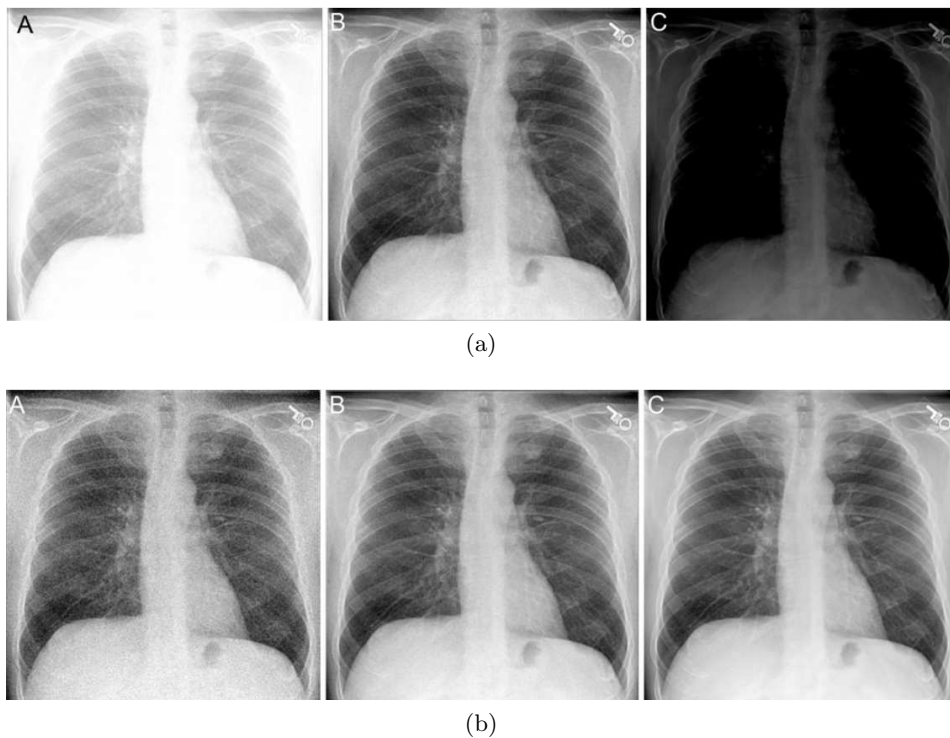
The exposure creep in digital radiography: (a) Screen-film imaging; (b) Digital imaging. The capital letters indicate: (A) underexposure; (B) correct exposure; (C) overexposure. The images are extracted from the paper by Seibert and Richard (2011).*
